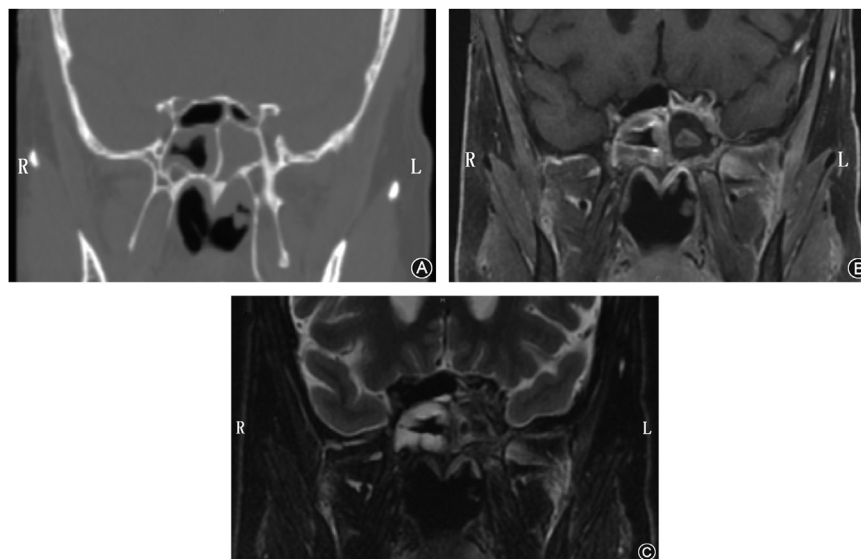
CT and MRI imaging for Case #1. A: CT-scan coronal view without contrast demonstrating complete opacification of the left sphenoid sinus; no speckled calcifications noted; B: Coronal MRI T1 with contrast demonstrating left sphenoid central signal hyperintensity with surrounding rim of hypointensity; C: MRI T2 coronal view demonstrating loss of signal intensity within the left sphenoid, suggestive of fungal sinusitis and possible IFS.
